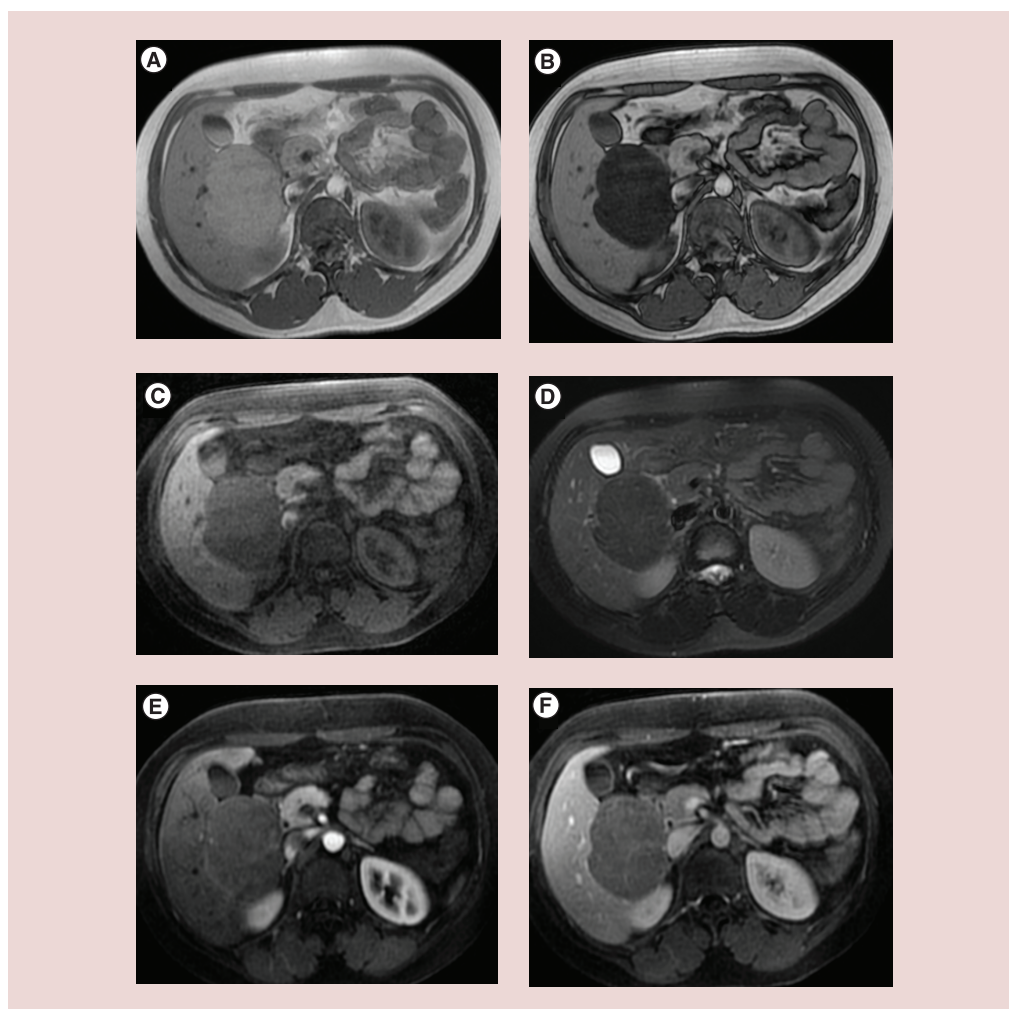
Imaging features of *HNF1A* inactivated hepatocellular adenoma. Large *HNF1A*-inactivated hepatocellular adenoma (HCA) in a 26-year-old woman. In chemical shift T1-weighted sequence, HCA has moderate hyperintensity in-phase (A), with a marked signal dropout on opposed-phase images (B). The lesion is hypointense in both T1 (C) and T2 (D) fat-suppressed sequences due to the lipid content. After contrast medium injection, there is only slight arterial enhancement (E), but the lesion remains hypointense compared with the normal liver on portal venous phase (F).
